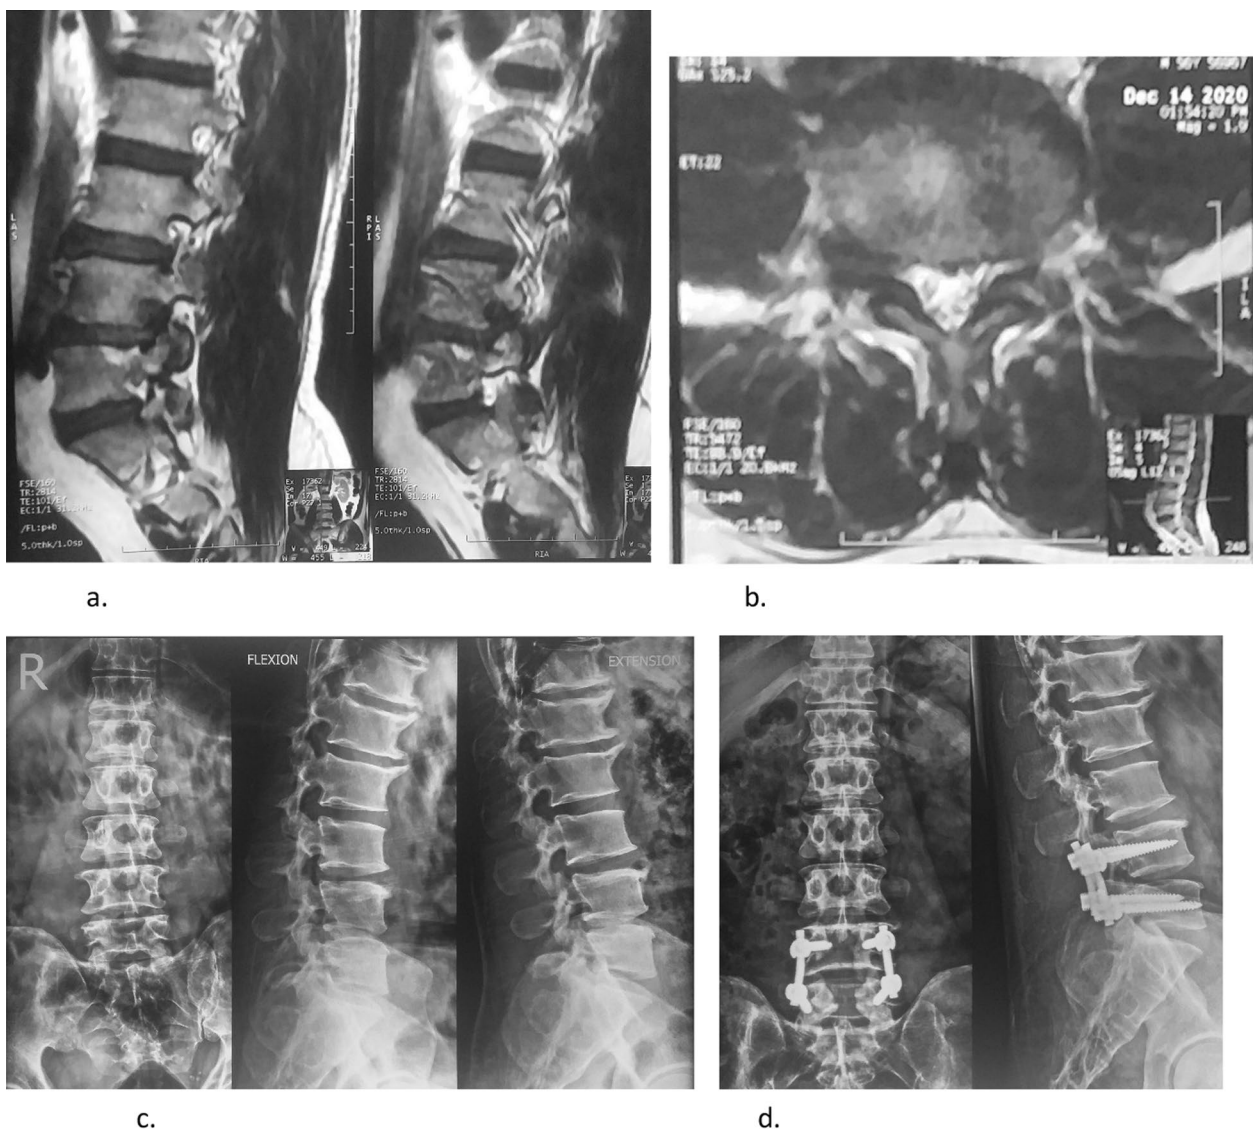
Rt L3-4 FLLDH. Male patient 43 y old presented with Rt femoralgia and weakness of the quadriceps muscle. a and b preoperative MRI LSS axial and sagittal views showed L3-4 Rt foraminal and far lateral LDP compressing Rt L3 root. c and d postoperative X Ray LSS. surgical treatment was done with L3-4 laminectomy and Rt L3-4 full facetectomy, discectomy and removal of the extruded fragment, and L3-4 fixation with transpedicular screws. Marked improvement of pain and weakness was observed immediately postoperatively (Excellent outcome)
